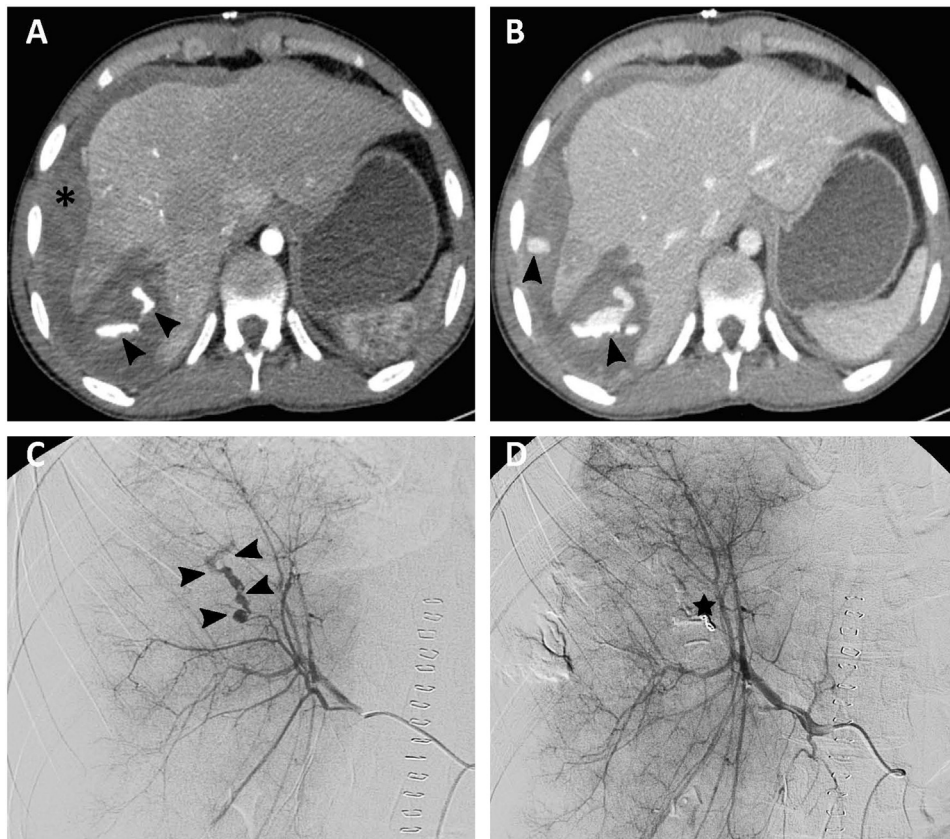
Embolization for liver trauma. A 16-year-old patient who had sustained an AAST grade 3 liver trauma after a scooter accident: active bleeding detected on total body CT upon arrival. Nine days after removal of initial damage control hepatic packing performed for major hemodynamic instability, the patient developed sudden hypotension and abundant bleeding via the drains. Emergency CT showed massive active contrast extravasation during the arterial phase (arrow heads image A), increasing during the venous phase (arrow heads image B), and bleeding into the perihepatic peritoneal space (asterixes A et B). Selective hepatic arteriography localized the active bleeding in segment VII. Microcoil embolization was delivered with a microcatheter (black star image D). Final angiography showed occlusion of the injured vessel (image D).
